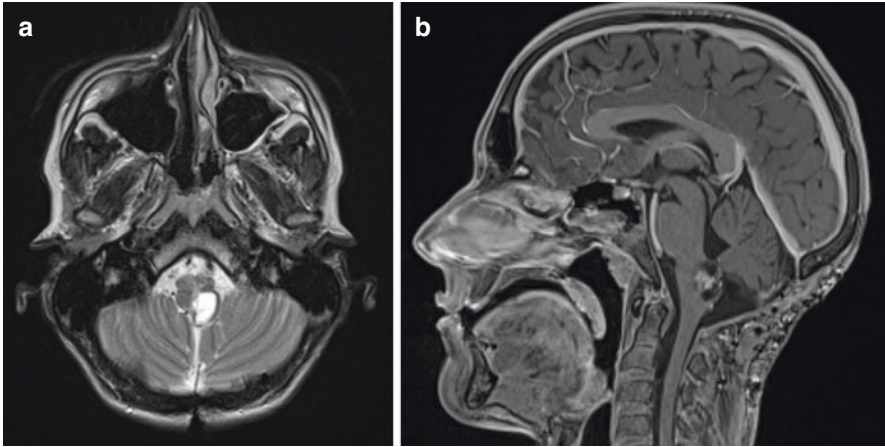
Focal Brainstem Tumor. (a) Axial T2 weighted MRI demonstrating a T2 hyperintense lesion isolated to the left posterior medulla with encroachment on the Foramen of Magendie. (b) Sagittal T1 weighted MRI with contrast demonstrating heterogenous contrast enhancement of the posterior medullary focal lesion
